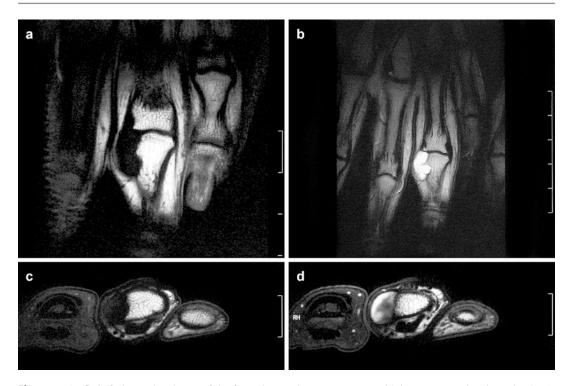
(a–d) Soft tissue chondroma of the finger in a young woman: (a) coronal spin-echo T1-weighted MR image; (b) coronal spin-echo T2-weighted MR image; (c) transverse spin-echo T1-weighted MR image; (d) transverse spin-echo T1-weighted MR image after gadolinium contrast injection (same level as in c). Lobulated soft tissue mass near the radial aspect of the proximal third of the basic phalanx of the fourth finger. On T1-weighted image
